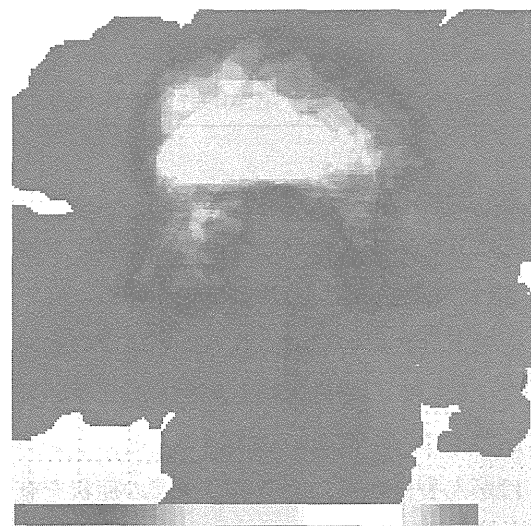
徒手筋力テスト3以下のがん脊椎転移患者の MRI axial 像における転移がんの位置
